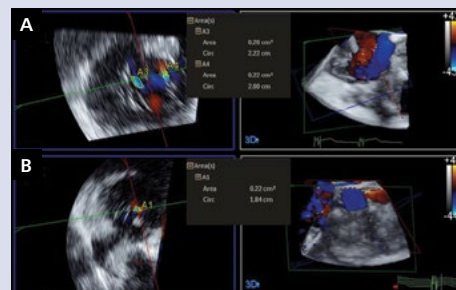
Three-dimensional transoesophageal echocardiography (TEE), low oesophageal view; A. Vena contracta area (VCA) planimetry of pre-procedural tricuspid regurgitation (TR), two jets: VCA₁ (A3) — 0.28 cm², VCA₂ (A4) — 0.22 cm²; B. Postprocedural TR jet: VCA₁ (A1) — 0.22 cm²
